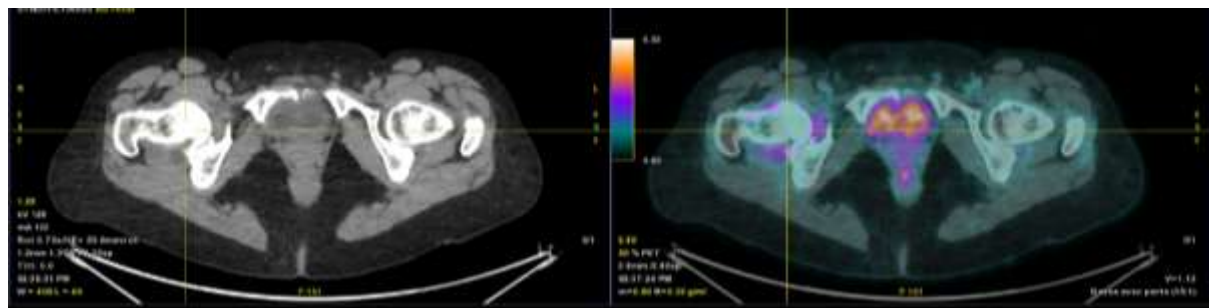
PET-CT findings showing the initial involvement of the vulva (axial view).
